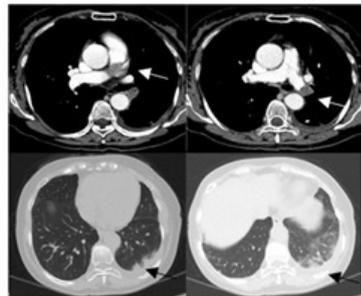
Initial chest CT angiography. CT scan shows that eccentric filling defects on main and left lower pulmonary artery, subpleural consolidation on left lower lobe, pleural effusion.
